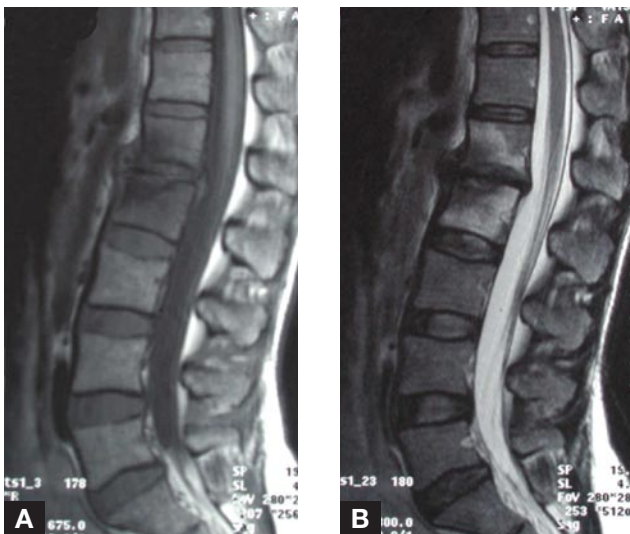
T₁-weighted (A) and T₂-weighted (B) magnetic resonance imaging scans show loss of L1–L2 disc space and endplate erosion with hypointense signal of both disc and endplate, atypical for infection. Hyperintense signal of vertebral body on T₂-weighted scan suggests edema.
